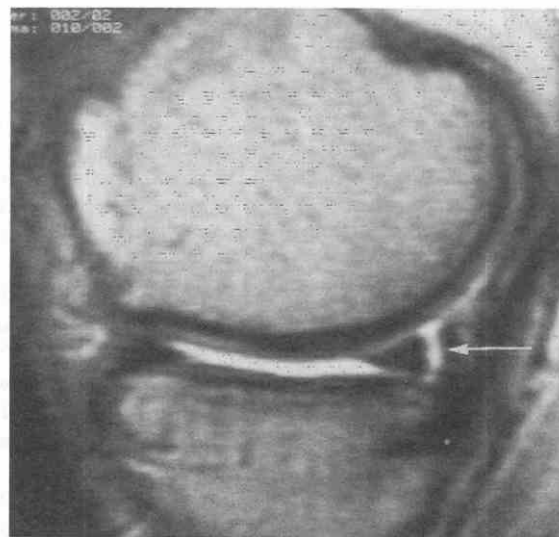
Peripheral tear. Sagittal T2-weighted images show high signal intensity at the periphery of the posterior horn of the medial meniscus (arrow). A joint effusion is present.
